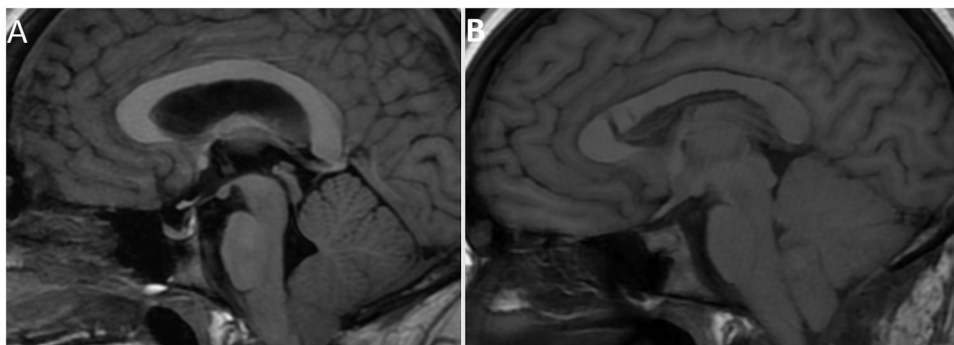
A) Pre-decompression sagittal T1 MR image of the midline structures demonstrates flattening of the pituitary gland within the sella. This is atypical for a 25-year-old female as she should have a relatively full pituitary gland with a convex upper margin. Also notice that the lateral, third, and fourth ventricles are slightly prominent. Additionally, there is cerebellar tonsillar herniation measuring 12 mm. B) Post-shunting sagittal T1 MR image demonstrates interval expansion of the pituitary gland within the sella. The shunt tract can be seen in the genu of the corpus callosum. The ventricles are now significantly more decompressed as well.
